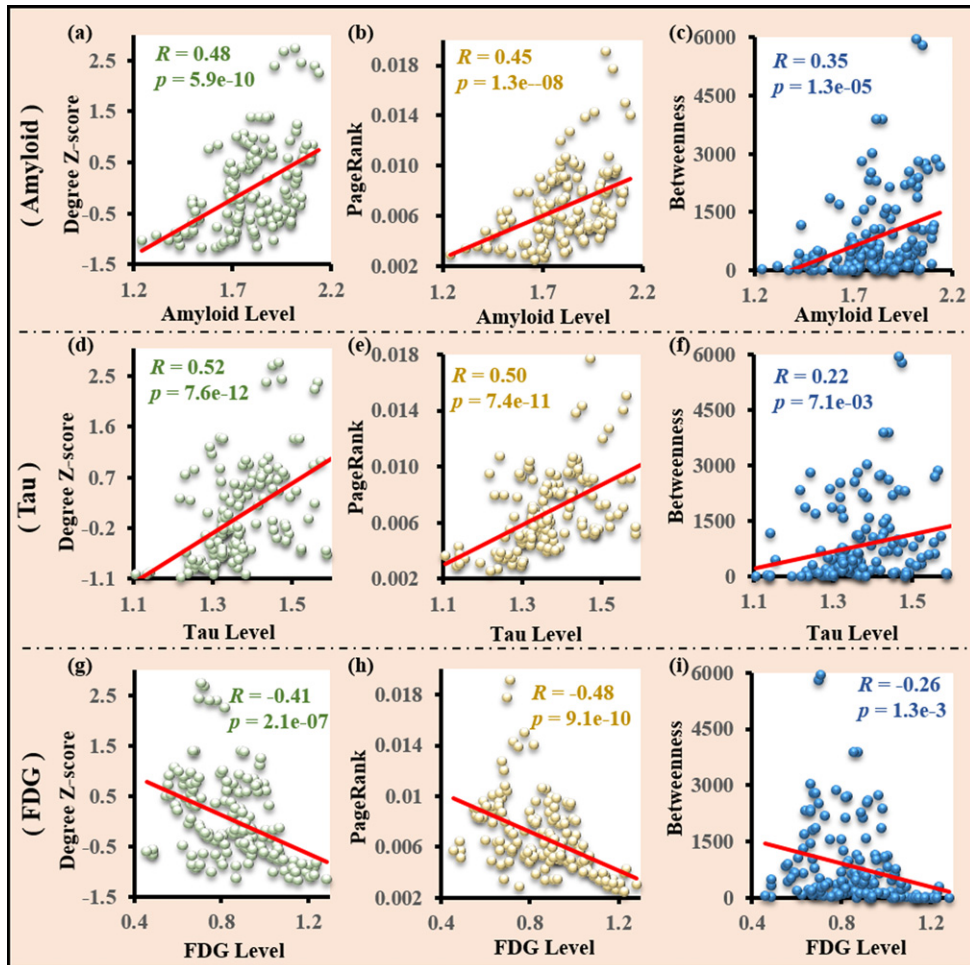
Graph-theoretic metrics versus pathological damage (amyloid- β , tau, or FDG) SUVR level at each node of brain network. In each row, the three subfigures in left-to-right order describe the results of the three centrality measures, Degree Z-score, PageRank, and Betweenness. Across the first two rows of the graph, the greater the centrality measure of nodes (i.e., the stronger the hub attribute of nodes), and the higher the amyloid or tau level at the corresponding nodes will tend to be. FDG appears opposite to the first two biomarkers in the last row.
